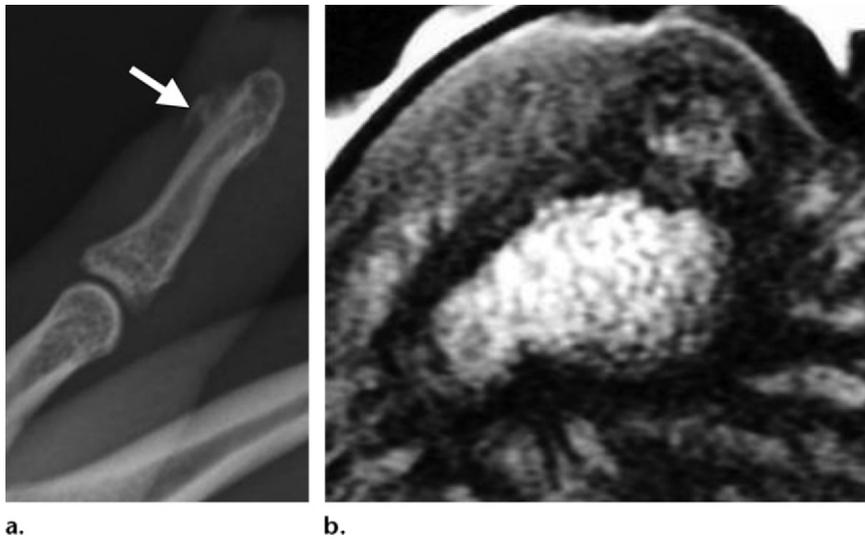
Subungual exostosis. (a) Lateral radiograph demonstrates a bone spur (arrow) in the region of the nail bed. (b) Short-axis proton-density-weighted MR image obtained in a different patient demonstrates a subungual bone spur originating from the cortex, with no continuity of bone or marrow.
